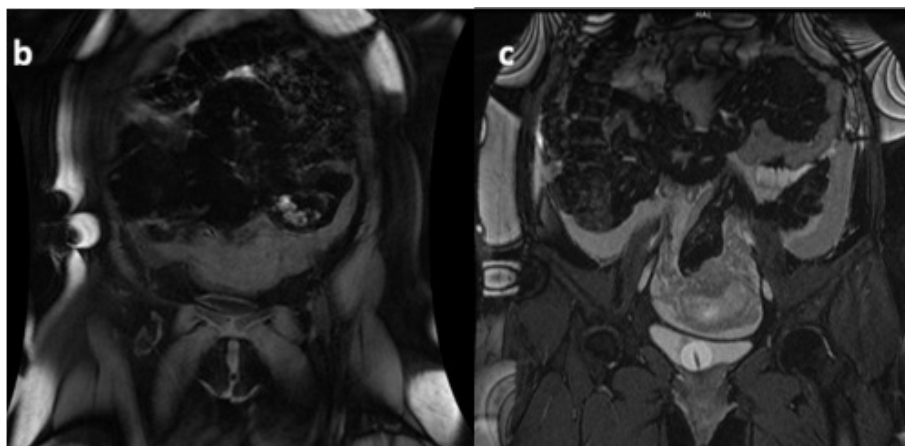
MRI revealing findings consistent with an ectopic gestational focus coexisting with an intrauterine pregnancy.
